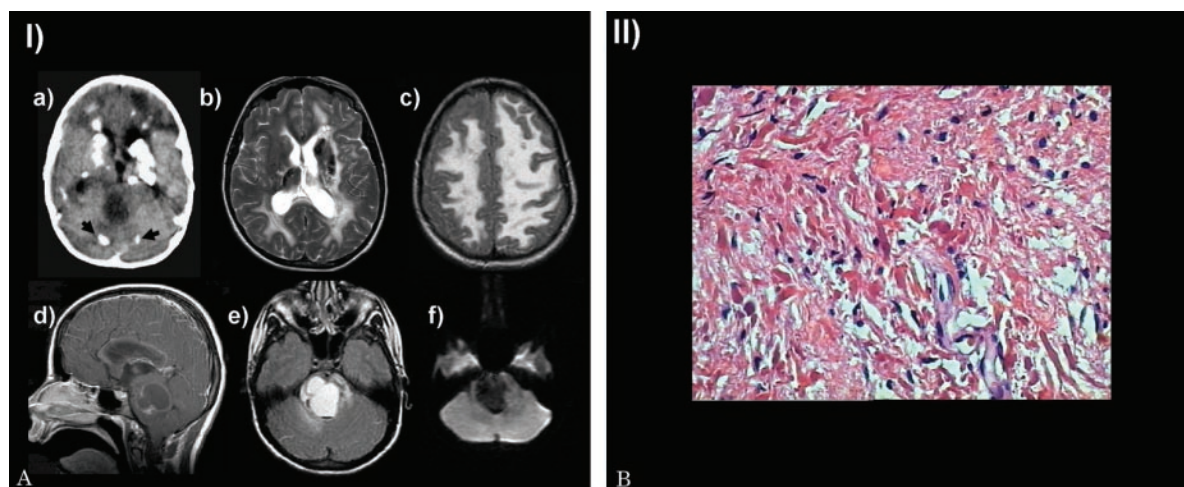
Patient 3. I. Nonenhanced CT (A) shows calcifications in the cerebellum and dentate nuclei (black arrow). Note the posterior fossa midline cyst. Axial T2-weighted image (B) shows calcifications and white matter hyperintensity. Axial fluid-attenuated inversion recovery image (FLAIR) (C) shows extensive white matter abnormalities. Sagittal postgadolinium T1-weighted image (D) shows enhancement around the cyst. Axial FLAIR (E) shows high signal in the cyst, reflecting high protein content, although diffusion-weighted image (F) shows no water restriction (hyposignal). II. Fibroglial tissue with conspicuous formation of Rosenthal fibers; H-E, $\times 400$.
